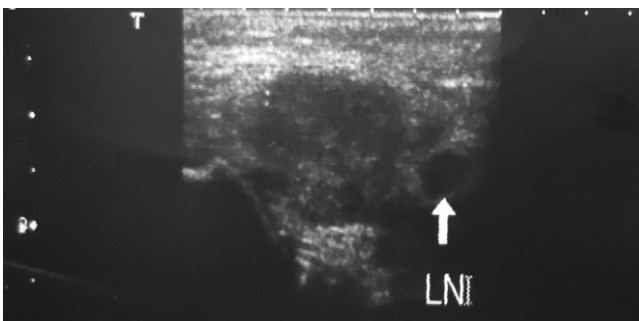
Sonogram of right parotid gland shows increased gland size with hypoechoic area and intraparotid lymph nodes of millimeters in diameter.
